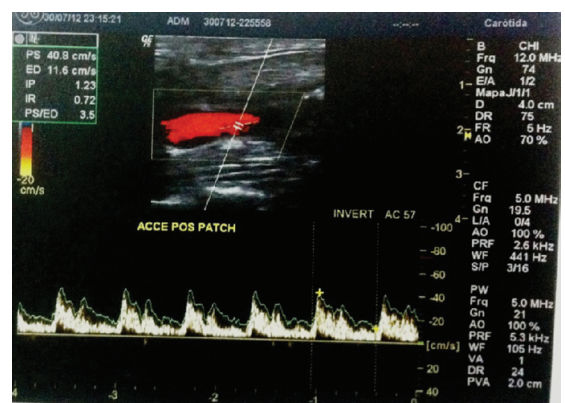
Postoperative outpatients follow-up Doppler ultrasound showing normal flow inside the left common carotid.
